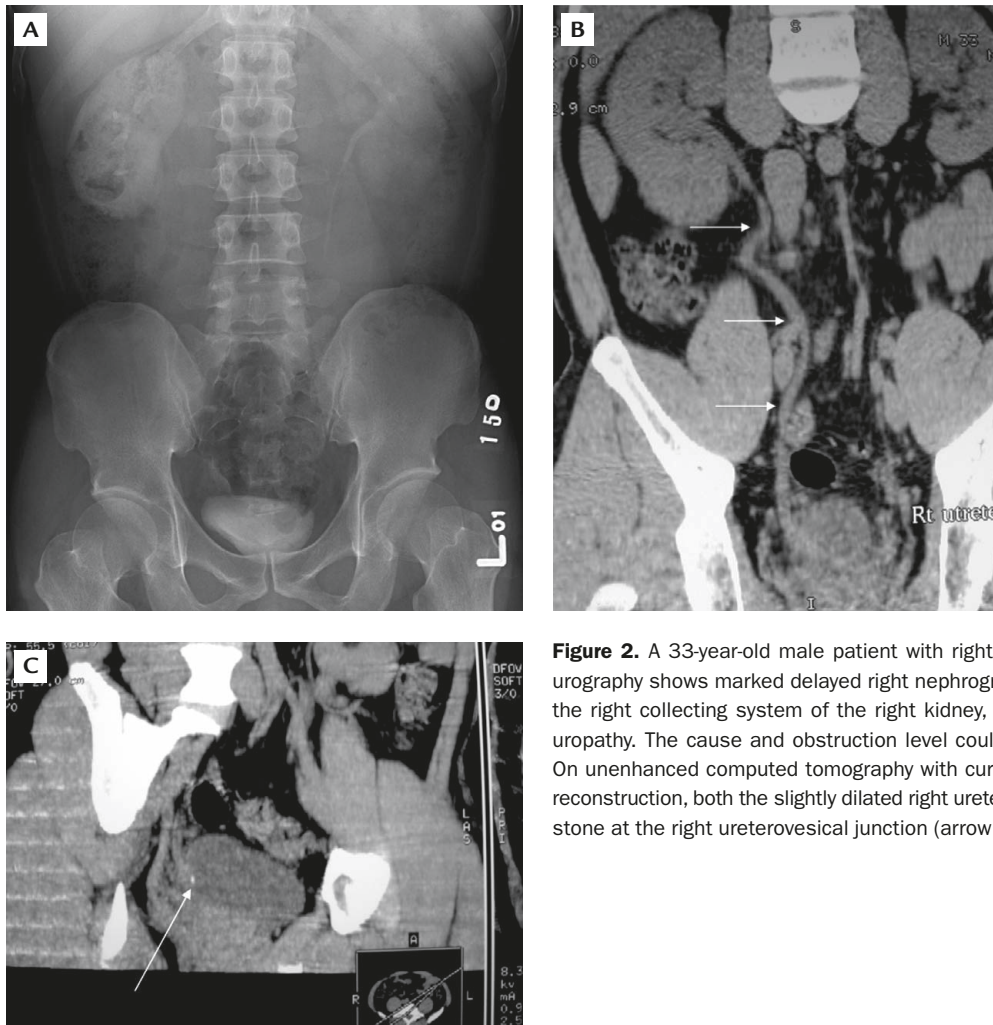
A 33-year-old male patient with right renal colic. (A) Intravenous urography shows marked delayed right nephrogram and non-opacification of the right collecting system of the right kidney, indicating acute obstructive uropathy. The cause and obstruction level could not be determined. (B, C) On unenhanced computed tomography with curved multiplanar reformatted reconstruction, both the slightly dilated right ureter (arrows in B) and the small stone at the right ureterovesical junction (arrow in C) were demonstrated.
